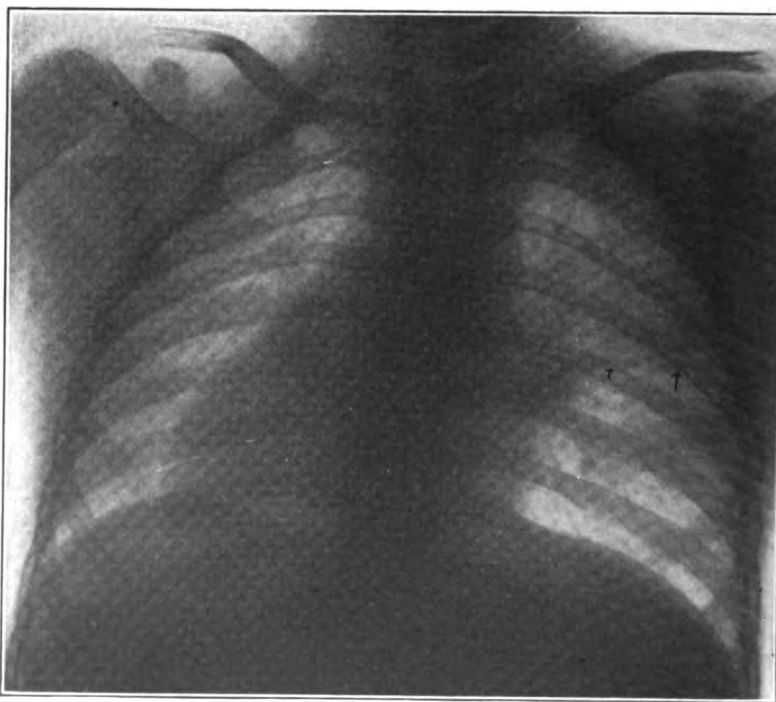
(Case 1). Radiograph taken March 25, 1915. Absence of hilus infiltration. Persistence of thickened interlobar fissure. Enlarged bronchial lymph nodes.
